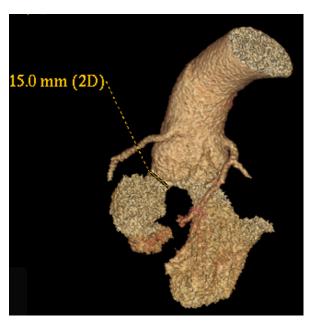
Computed tomogram (3-dimensional reconstruction) shows a fistula 15 mm in diameter (dotted line) between the right sinus of Valsalva aneurysm and the right ventricular outflow tract. The failure of left ventricular filling indicates severe aortic regurgitation.
